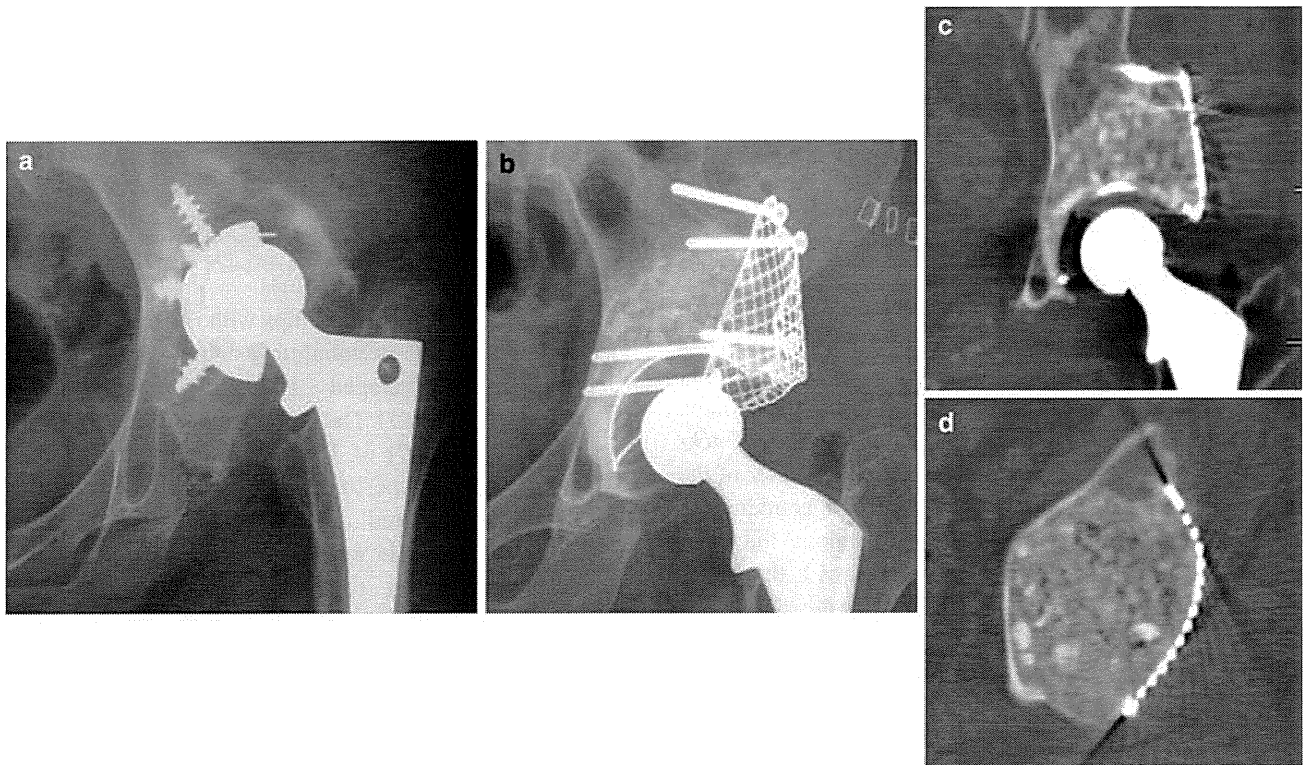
Radiographs and CT images of the clinical cases. a Loosening of the acetabular component was revised using the impaction bone grafting technique. A postoperative radiograph b and CT images (c, d) show well-compacted bone grafting in an AAOS type 3 acetabular defect
